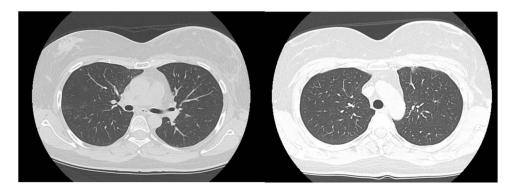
TC scan of young patient treated with adjuvant abemaciclib and letrozole for high risk hormone receptor positive breast cancer. The CT scan performed after one year of abemaclib showed ground-glass area with bilateral 4–5 millimeters opacities suspected for inflammatory interstitial lung disease. Patient was asymptomatic. Bronchoalveolar lavage (BAL) was performed showing only inflammatory cells. Abemaciclib was prudently stopped. The HRTC scan performed two months later showed complete radiological resolution. Patients re-started and completed adjuvant abemaciclib with no further pulmonary complication.
